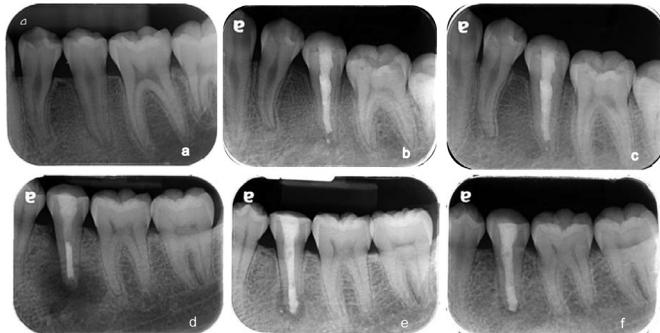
Two representative cases of an orthograde apical barrier with Bio-MA. Preoperative radiographs of a mandibular left second premolar (a), Bio-MA orthograde apical barrier (b), Periapical lesion healed at the 15-month recall (c). Pre-operative radiographs of a mandibular left second premolar (d), Bio-MA orthograde apical barrier (e), Periapical lesion healing at the 14-month recall (f).
